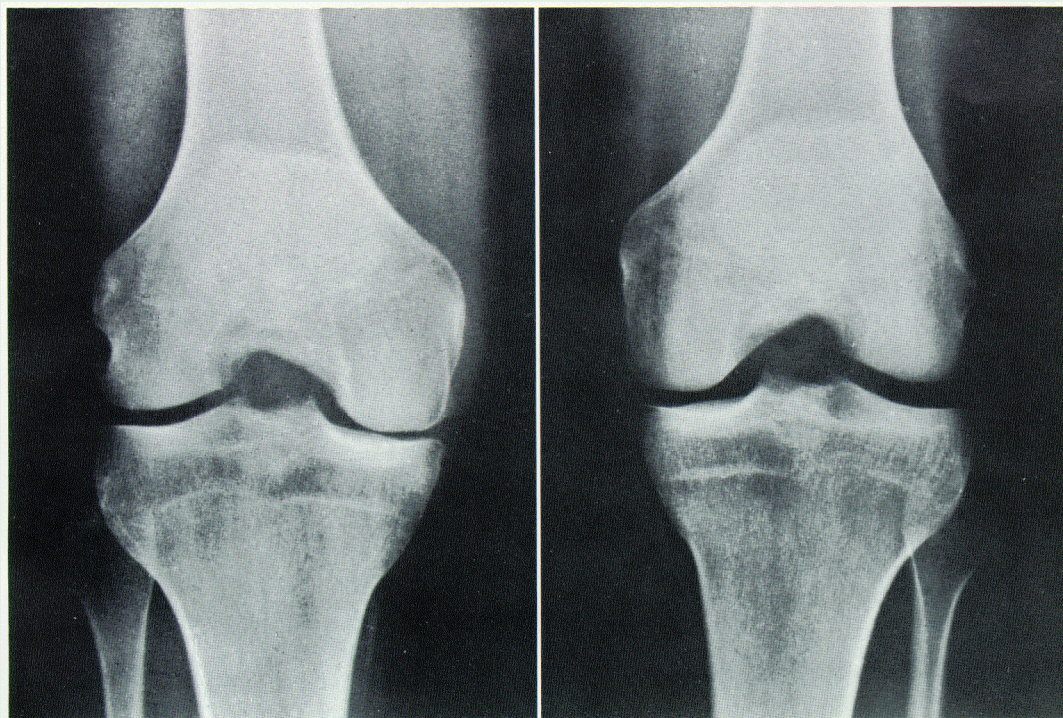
Case 2. X-ray Only slight narrowing of the articular space on the right.
